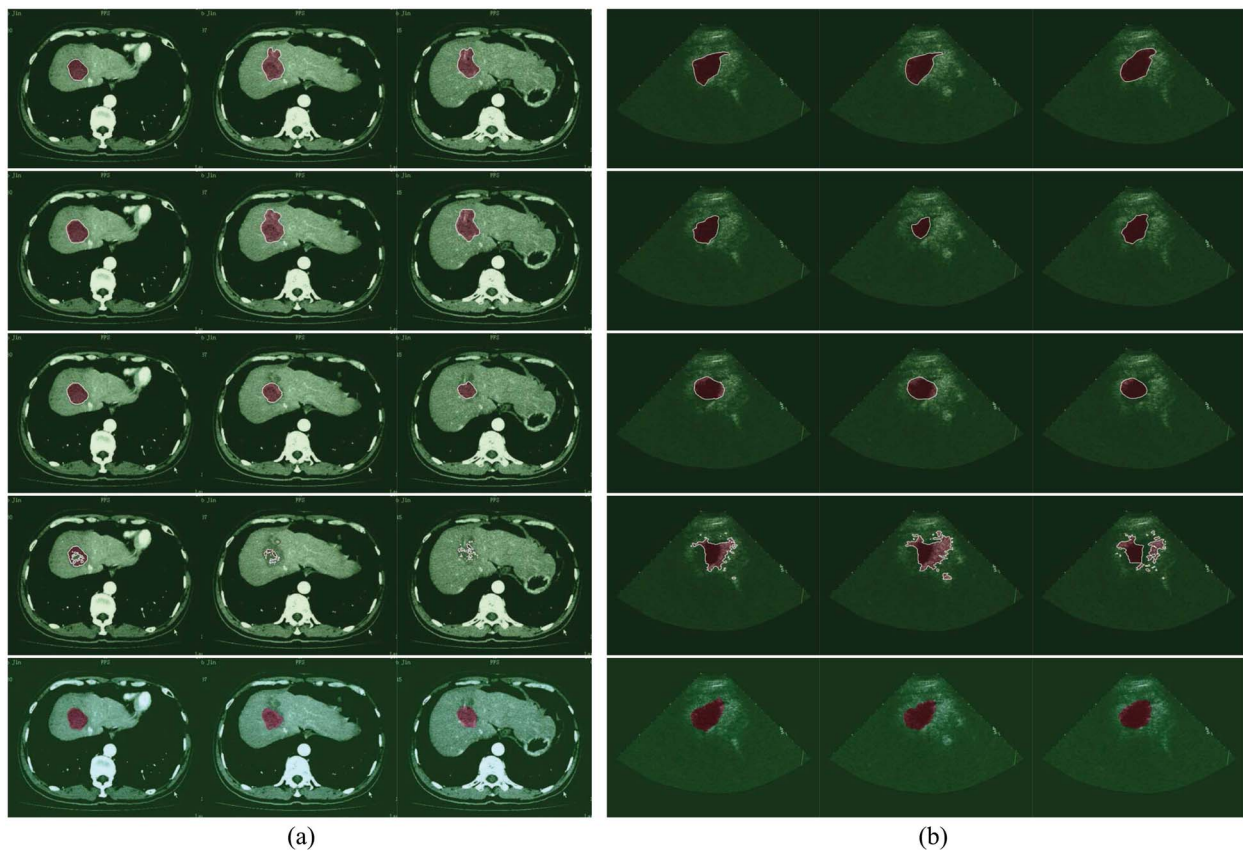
Comparison of the proposed method (second row) with CVM [17] (third row), HLM [18] (fourth row), and RotoBrush [48] (fifth row). The ground-truth annotations are shown in the top row. (a) 8th, 15th, and 23rd slices of the CT volumetric images. (b) 238th, 242nd, and 249th frames of the US image sequence.
